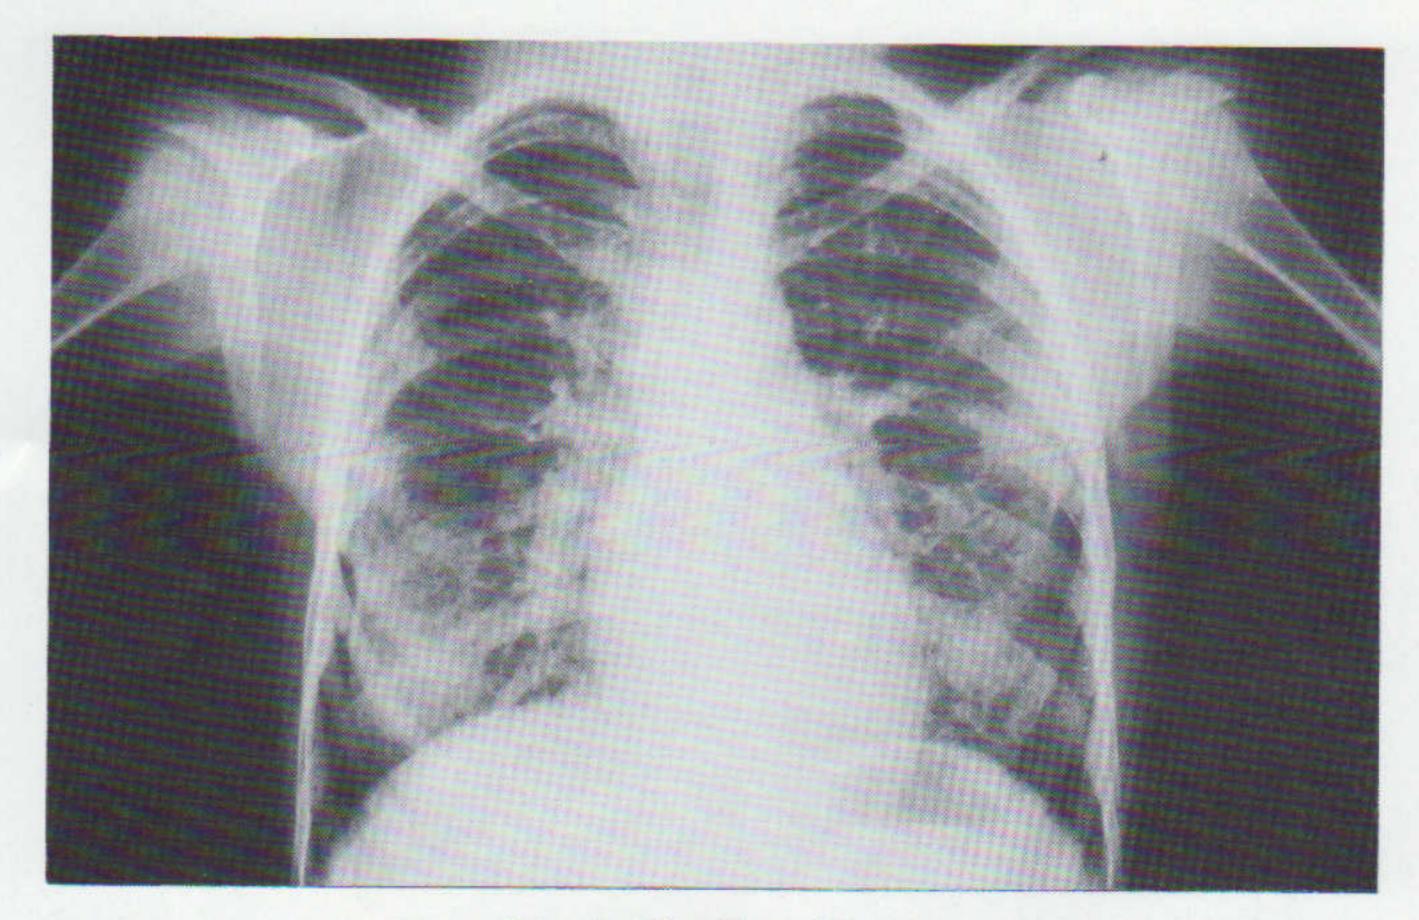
Chest X-ray of Case 1.
